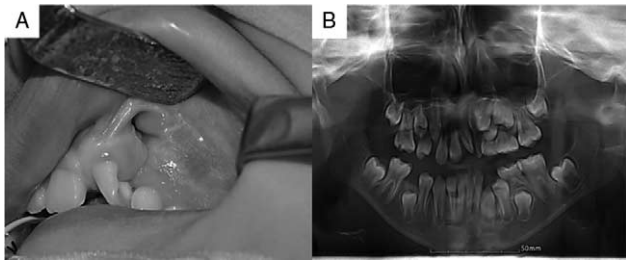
Photograph and radiograph of the patient before transplantation. (A) Intraoral photographic view and (B) panoramic radiographic view.
